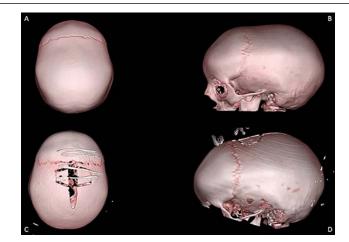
Scaphocephaly type A-B: Preoperative 3D computed tomography, C-D: Postoperative 3D computed tomography
